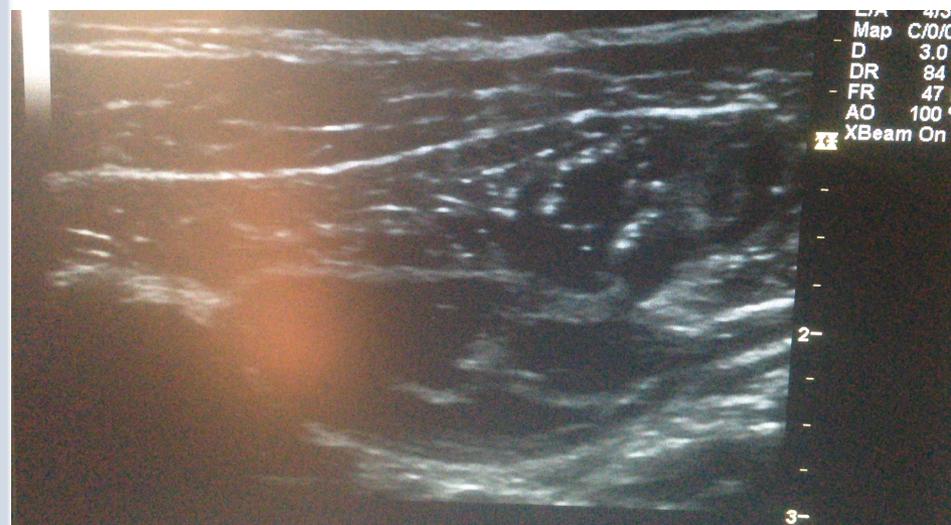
Ultrasound image of the IL and IH nerves between the internal oblique and transverse abdominal muscles, 5 cm cranial and slightly lateral to the anterior superior iliac spine. The IL nerve is encircled by dots to define the circumferential border of the nerve and to allow the ultrasound machine to calculate the cross-sectional area of the nerve. 1, external oblique muscle; 2, internal oblique muscle; 3, transverse abdominal muscle.
